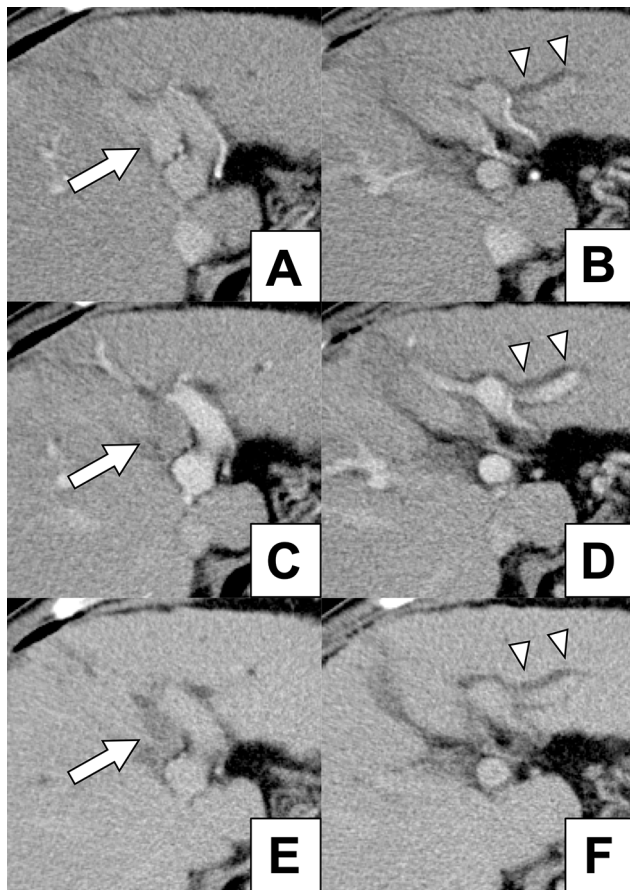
Contrast-enhanced computed tomography prior to transarterial chemoembolization: (A, B) arterial phase, (C, D) portal phase, and (D, E) equilibrium phase. Left panels show intraductal tumor invasion (white arrows). The intraductal tumor has a typical contrast-enhancement pattern of hepatocellular carcinoma, which shows arterial enhancement in the arterial phase and washout in the equilibrium phase. Right panels show dilatation of the left intrahepatic bile duct (white arrowheads).
